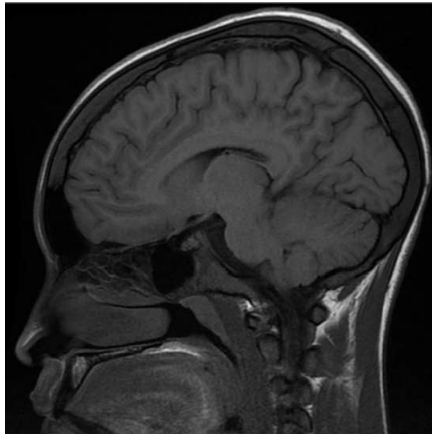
Follow-up MRI showing interval resolution of previously seen subgaleal collections and cephalohematomas.
